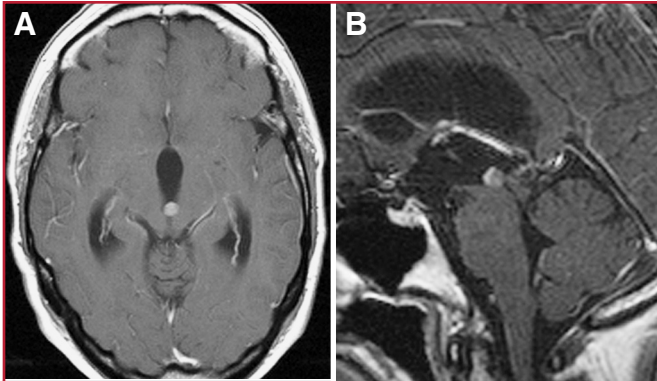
A 49-year-old woman presented with headache, nausea, and vomiting. T1-weighted sagittal (A) and axial (B) magnetic resonance imaging (MRI) scans revealed a small, contrast-enhancing lesion obstructing the aqueduct and thereby inducing triventricular hydrocephalus.
